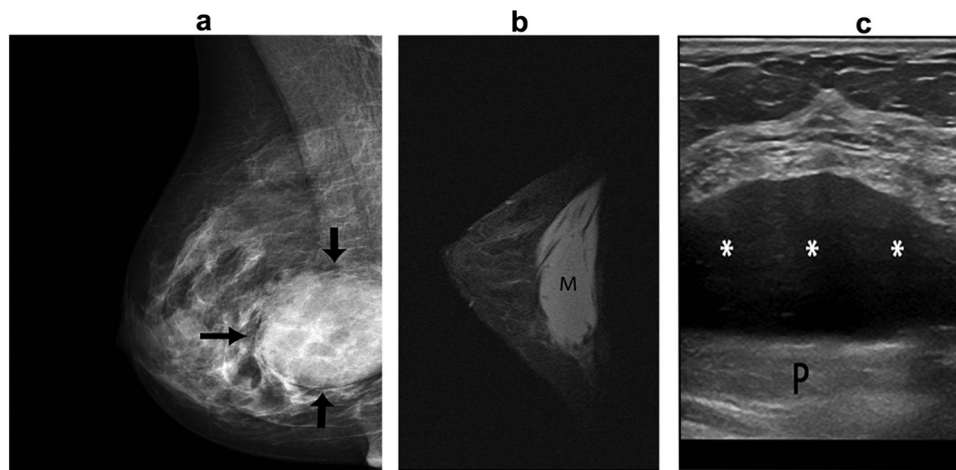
(a) Appearance of Macrolane on digital mammography (right medio-lateral oblique [MLO] view): well-circumscribed mass (arrows) of low to medium density is seen. (b) Typical appearance of Macrolane (M) by MRI (using Sagittal Short T1 Inversion Recovery [STIR]) 12 months after treatment. (c) Typical appearance of Macrolane by ultrasound (transverse close to the nipple) 12 months after treatment. Macrolane (*) superficial to pectoralis muscle (P) and deep to breast gland.
